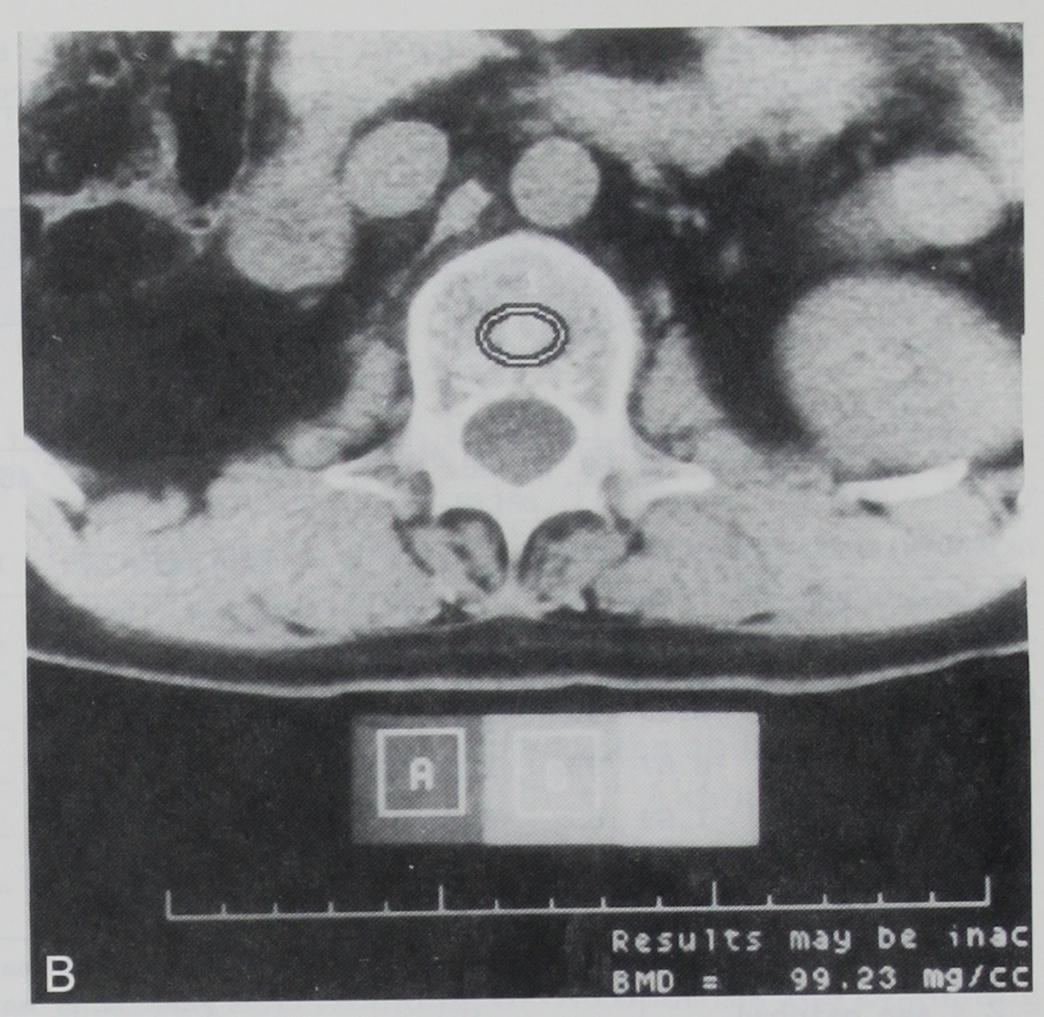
Quantitative computed tomographic scan. Placing the region of interest in the anterior (A) versus the posterior (B) aspect of the vertebral body results in a density difference of 73.45 mg/ml versus 99.23 mg/ml.
